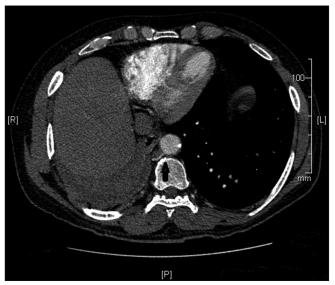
Axial computed tomography contrast raw image of case 2 showing hypertrophied vessel (black solid arrow) arising from the aorta
